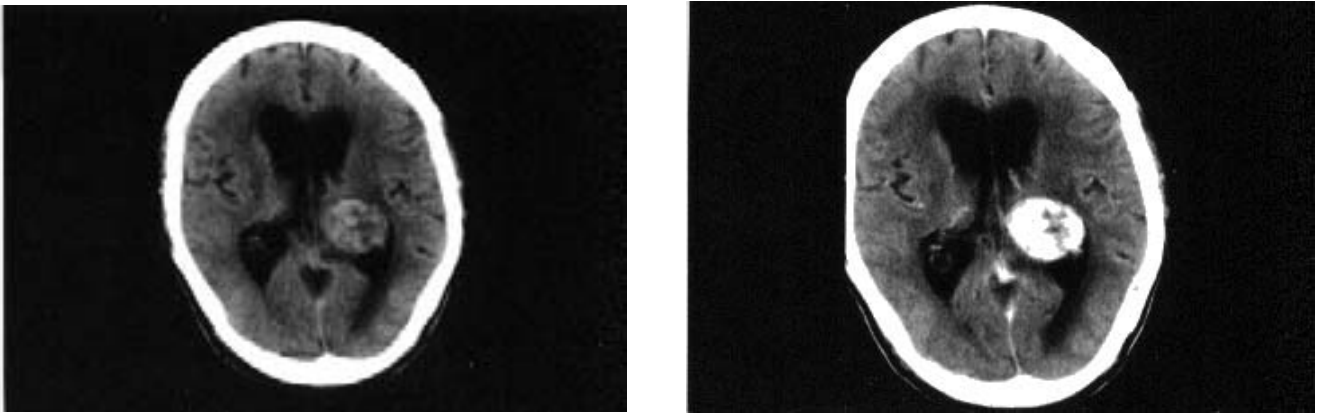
Preoperative computed tomography scan. Left: Plain scan showing an intraventricular tumor situated at the trigone of the left lateral ventricle with dilatation of the ipsilateral trigone and temporal horn; Right: Enhanced scan showing a homogeneous contrast enhancement.
